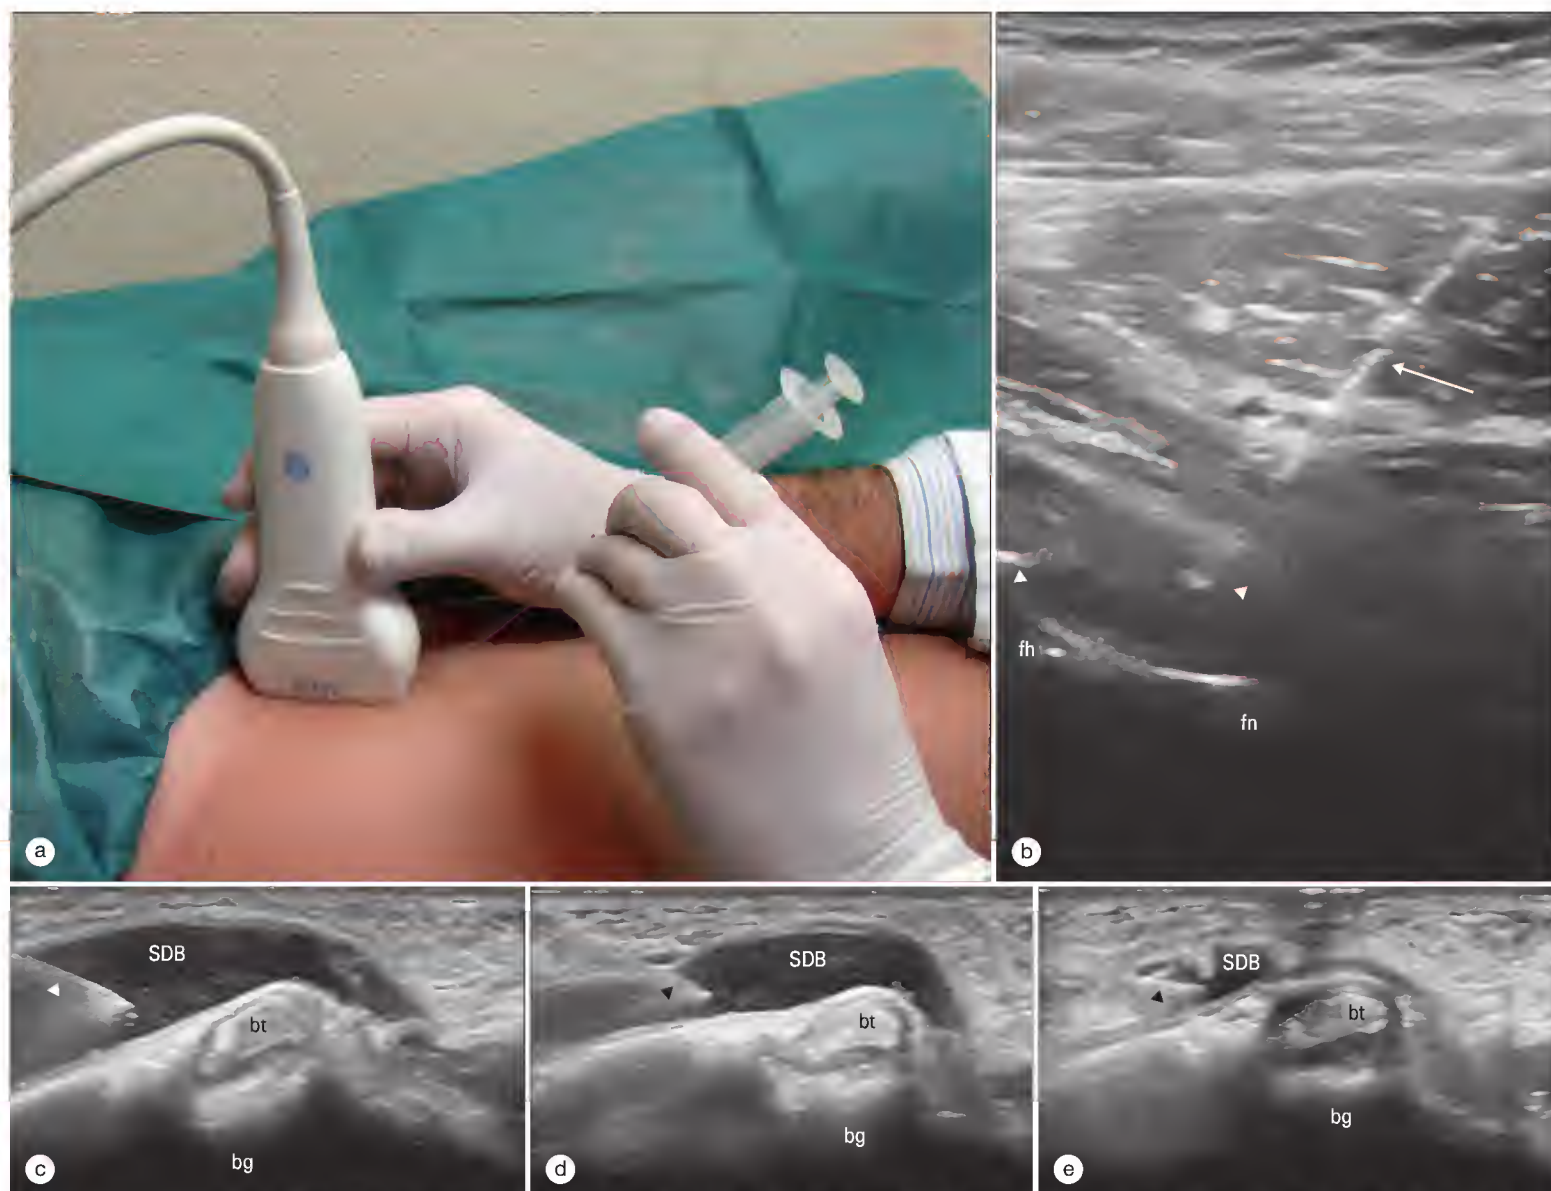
(a) Ultrasound-guided direct method of injection of the right hip joint. The needle is inserted adjacent to the transducer and directed to the anterior recess of the hip. (b) On the ultrasound image the tip of the needle (arrowhead) has a hyperechogenic appearance inside the hip effusion. The needle (arrow) appears hyperacute in the iliopsoas muscle. fh, femoral head; fn, femoral neck. (c) Ultrasound-guided injection of subdeltoid bursitis. (d and e) Successful fluid aspiration can be visualized in real time. Arrowheads indicate needle tips. bt, biceps tendon; bg, bicipital groove; SDB, subdeltoid bursa.
